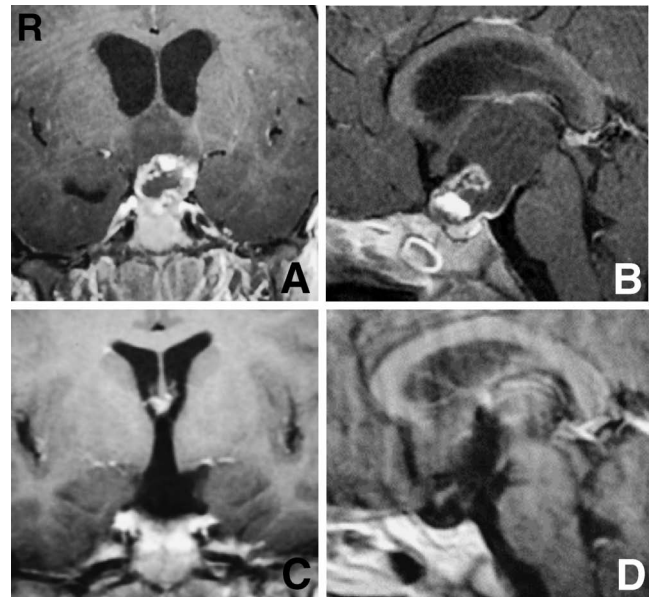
Case 1. Preoperative T_1 -weighted magnetic resonance (MR) images with contrast medium (A, B) showing a retrochiasmatic, partly cystic craniopharyngioma extending into the third ventricle, and postoperative T_1 -weighted MR images with contrast medium (C, D) showing removal of the tumor and slight damage to the left hypothalamus.
